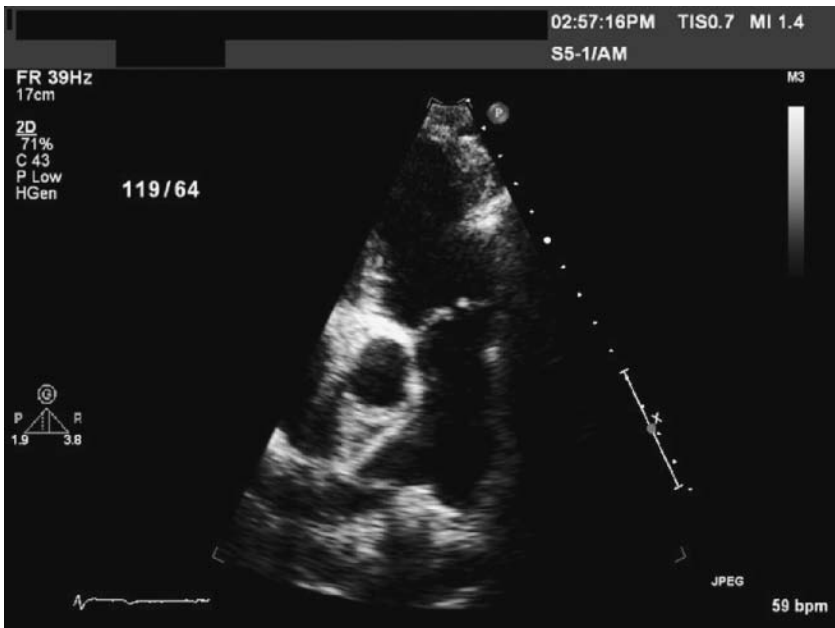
Thickened pulmonary valve leaflets seen by echocardiography in parasternal short-axis view of right ventricular outflow tract.
